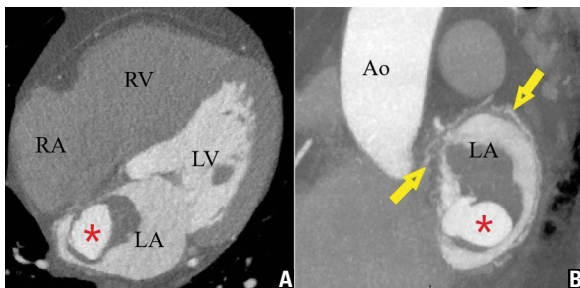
A. Axial arterial phase computed tomography image; B. Maximum intensity projection reconstruction of sagittal arterial phase computed tomography images. Images demonstrate the mass measuring 35×45 mm in the left atrium with its vascular and non-vascular components. They present enlarged, tortuous feeding vessels (yellow arrows on image B) and flush of arterial blood in the vascular nidus of the tumour (red asterisks on both images). The non-vascular part of the mass remains hypodense. Size of cardiac chambers is within normal limits. There are no other cardiovascular abnormalities; RA — right atrium; RV — right ventricle; LA — left atrium; LV — left ventricle; Ao — aorta.
